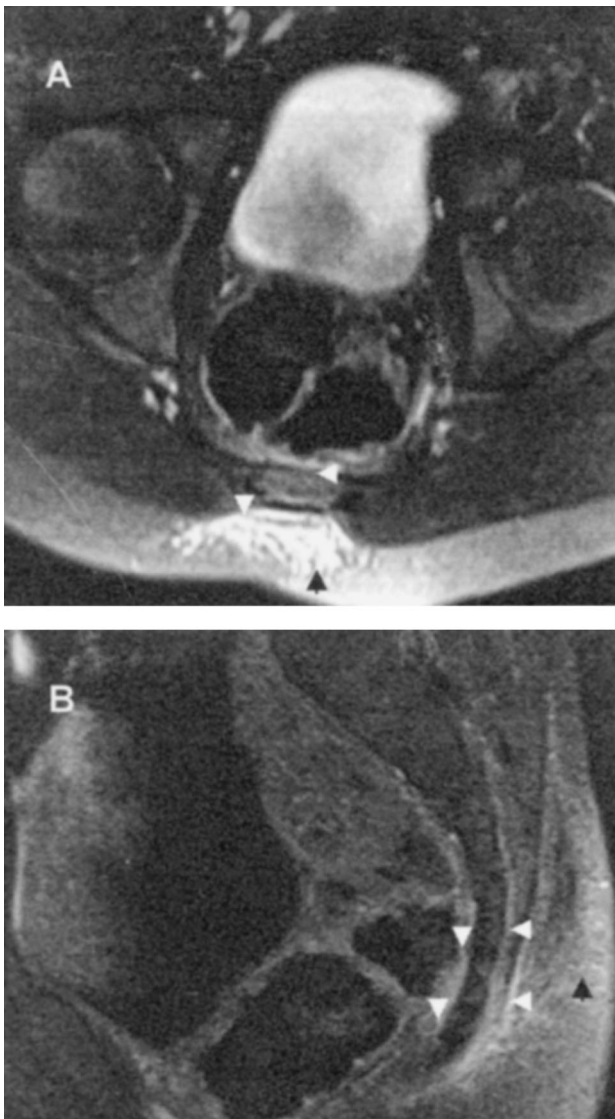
The initial horizontal T2-weighted magnetic resonance image (A) and the sagittal T1-weighted image with gadolinium (B) demonstrated a phlegmonous inflammation of the subcutis (black arrowheads) and an edema at the anteroposterior periosteum of the lower sacrum (S5) and the coccygeal bone as indirect sign of a beginning osteomyelitis (white arrowheads).
